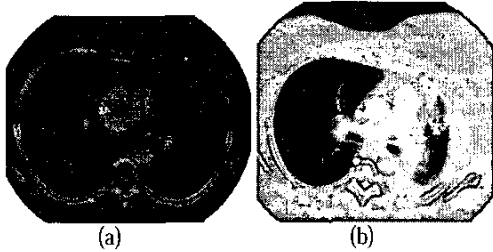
Sample images from two of the 75 CT lung cancer studies.
